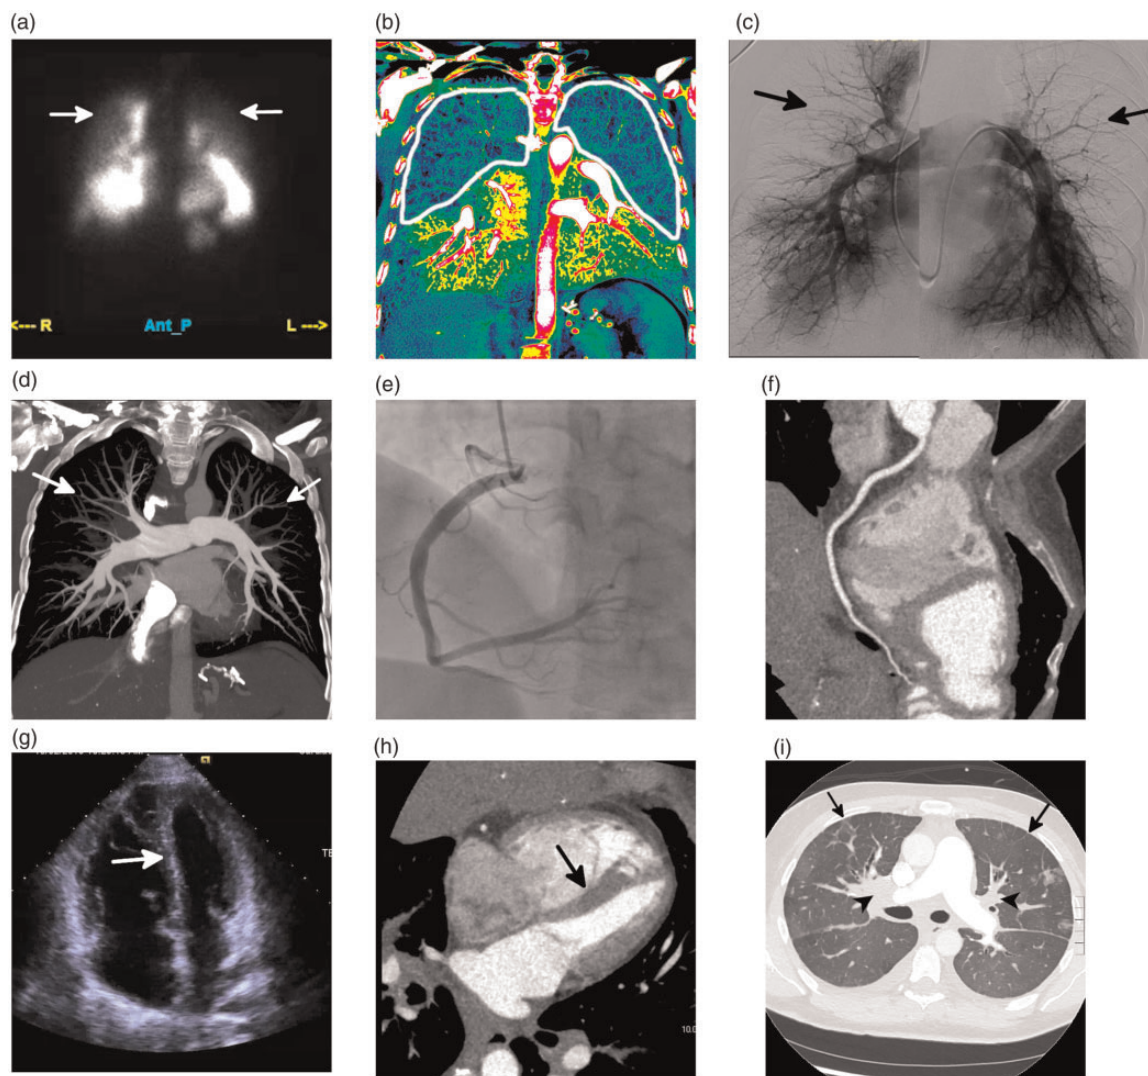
Side-by-side comparison of a traditional imaging workup for CTEPH, using multiple modalities, and a novel approach with a retrospectively gated coronary CT angiography (CTA) and dual-energy CT pulmonary angiography (DE-CTPA) acquired as a single exam. (a and b) An anterior image from a planar V/Q scan (a) shows decreased upper lung perfusion (white arrows), and coronal iodine map from the DE-CTPA study (b) shows decreased upper lobe and peripheral perfusion bilaterally (white outline). (c and d) Fused image of DSA (c) and a 20 mm thick maximum intensity projection from the DE-CTPA (d) both show peripheral pruning of the vasculature (arrows, c and d) but no evidence of chronic thromboembolic disease. (e and f) Images of the right coronary artery from a coronary catheterization (e) and a multiplanar reformat from the coronary CTA (f) both show that the vessel is free of disease. (g and h) Four-chamber image from an echocardiogram (g), and retrospectively gated coronary CTA (h) both show right ventricular hypertrophy and inversion of the interventricular septum (arrows, g and h). (i) An axial image of the lung from the single CTPA/coronary CTA study shows confluent perihilar soft tissue (black arrowheads) with prominent septal thickening (black arrows). Left ventricular function on both echocardiography and CTA was normal. The constellation of findings is highly suggestive of pulmonary veno-occlusive disease and not CTEPH. Continued medical management was recommended. This combined dual-energy CTPA and coronary CTA exam has both a lower cost and radiation dose compared with the traditional workup, which includes a V/Q scan, DSA, CTA, coronary angiogram, and echocardiogram. However, further studies are needed to assess the feasibility of this protocol. Source: Image supplied by the authors.
